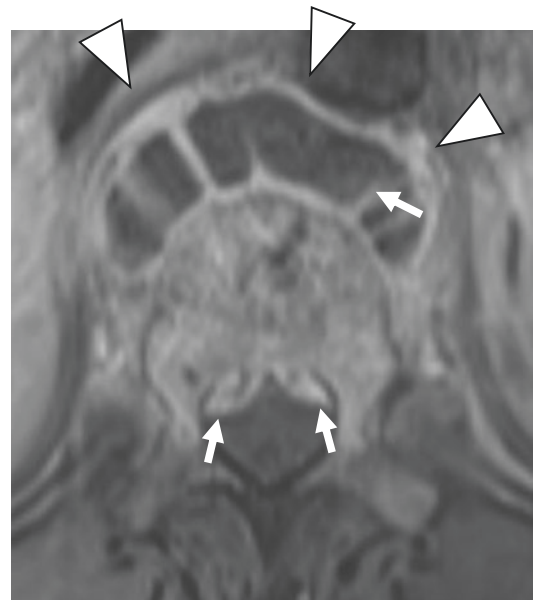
Tuberculous spondylodiscitis with bilobed epidural abscess. Axial contrast-enhanced T1-W MR image shows a bilobed epidural abscess (arrows). There is also a large anterior abscess (arrowheads)
